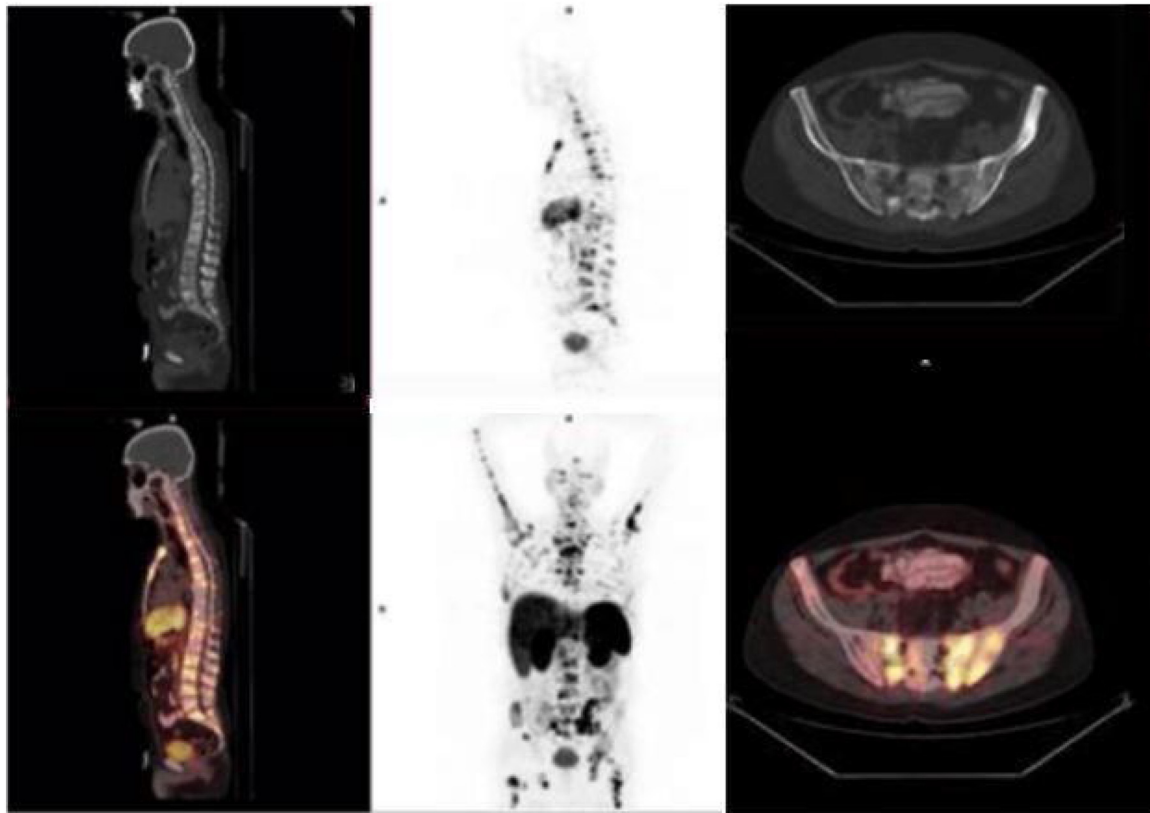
Sagittal and transaxial (PET/CT mode, left and right panels) and coronal (PET only mode, middle panel) ^{68}Ga -DOTATATE PET/CT. Multiple foci of high skeletal uptake corresponding to the bone metastases are evident.
